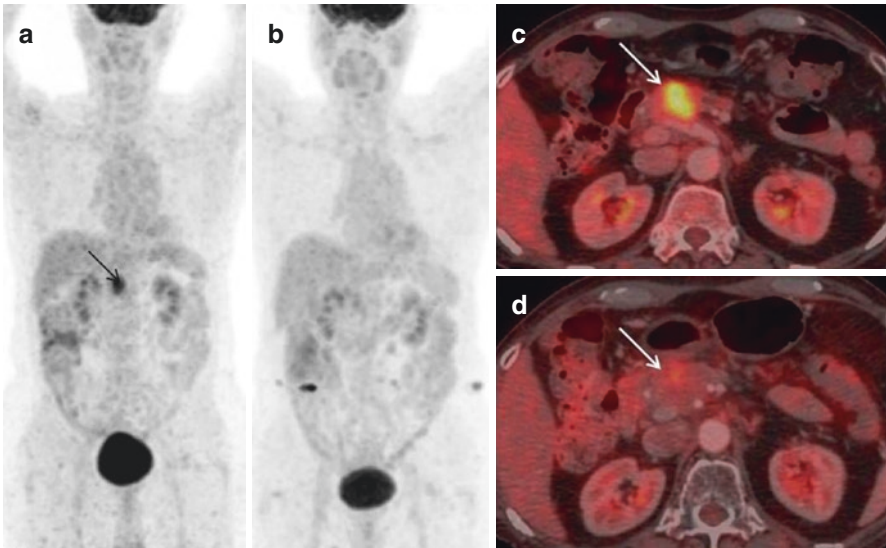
FDG PET/CT in treatment response evaluation. A 46-year-old female patient presented with adenocarcinoma involving pancreatic head which was non-resectable received 6# chemotherapy; PET/CT study was performed to assess treatment response. MIP images (baseline-a, posttreatment-b) show regression in focal tracer uptake in mid-abdomen, which is seen as significant regression in size with near-complete metabolic regression at the primary pancreatic site (baseline, with no new lesions elsewhere, on axial PET/CT (c-baseline, d-posttreatment)
